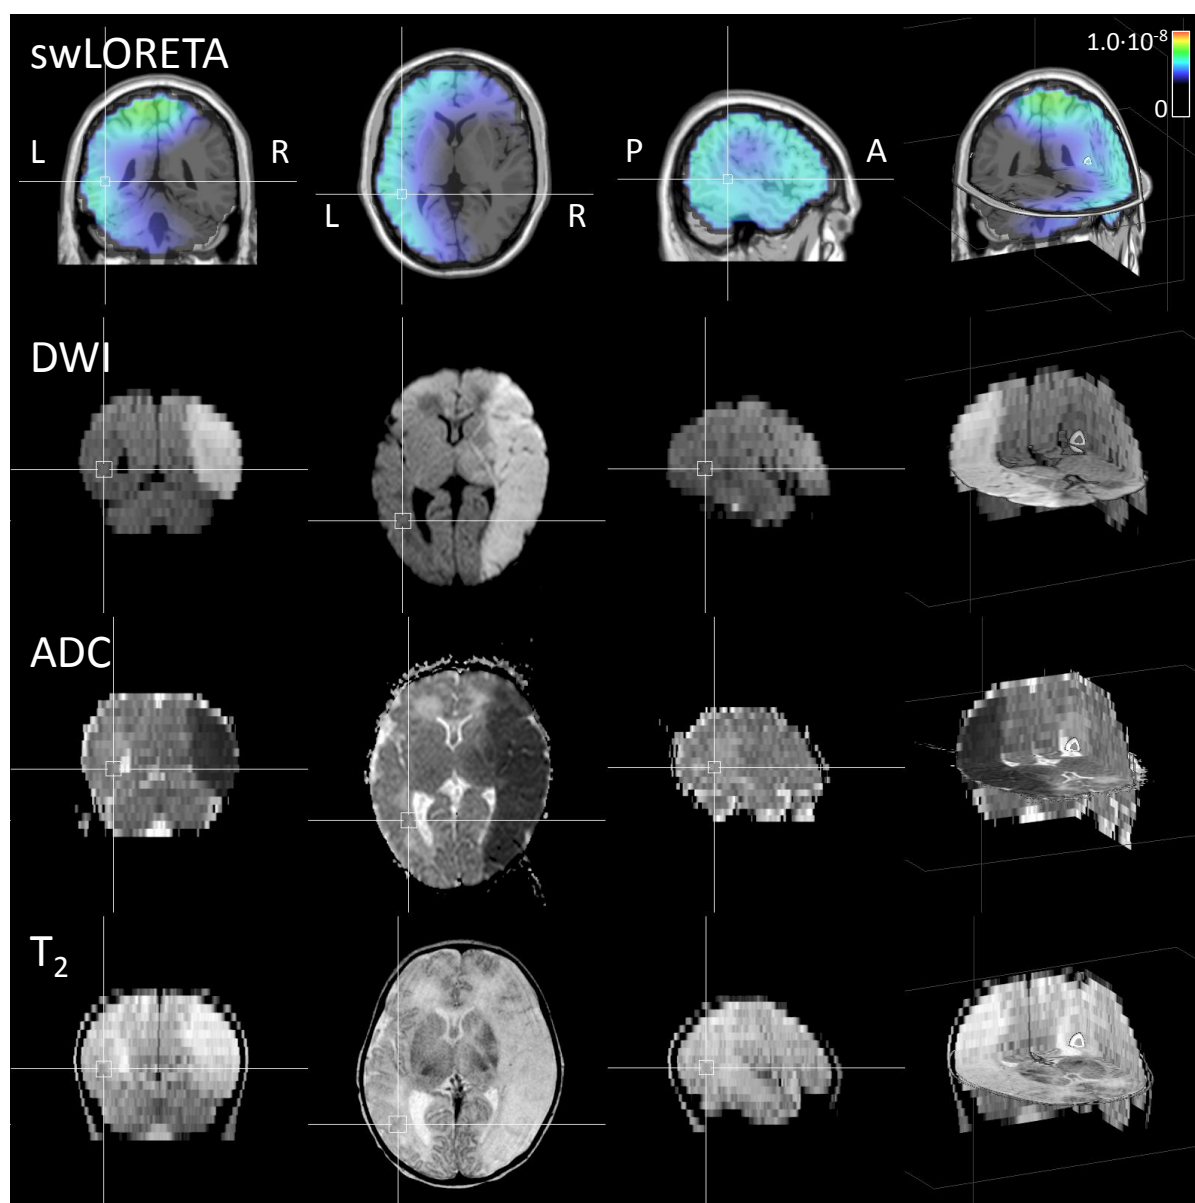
MRI images of patient 3 displayed together with the swLORETA inverse solution. The inverse solution indicates that most EEG activity is situated in the left hemisphere. MRI data shows a large MCA infarction in the right hemisphere.
